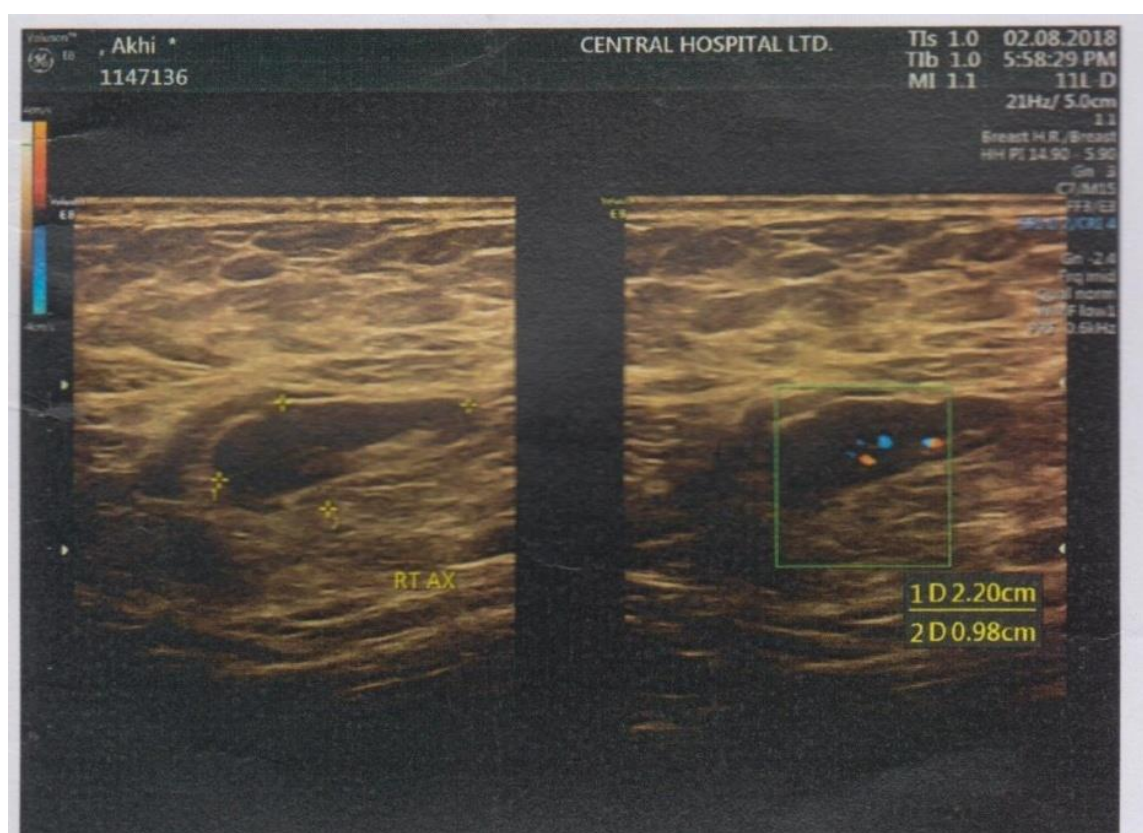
Shows Ultrasonography scoring of patients suspecting breast tuberculosis.
